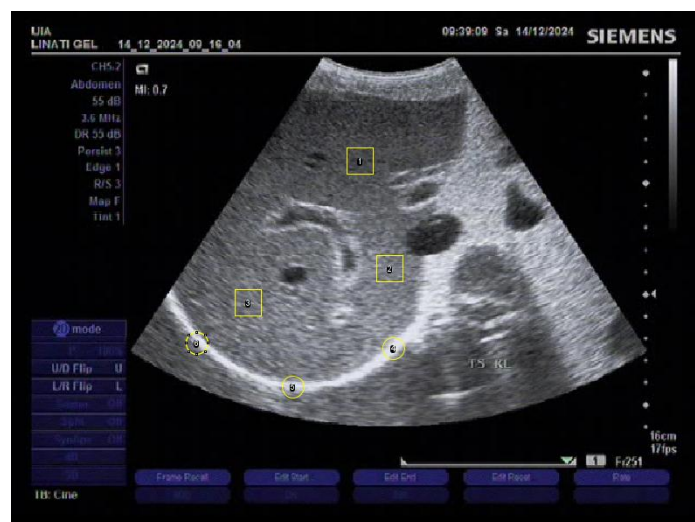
Ultrasound Image of the Liver with ROI Markings
